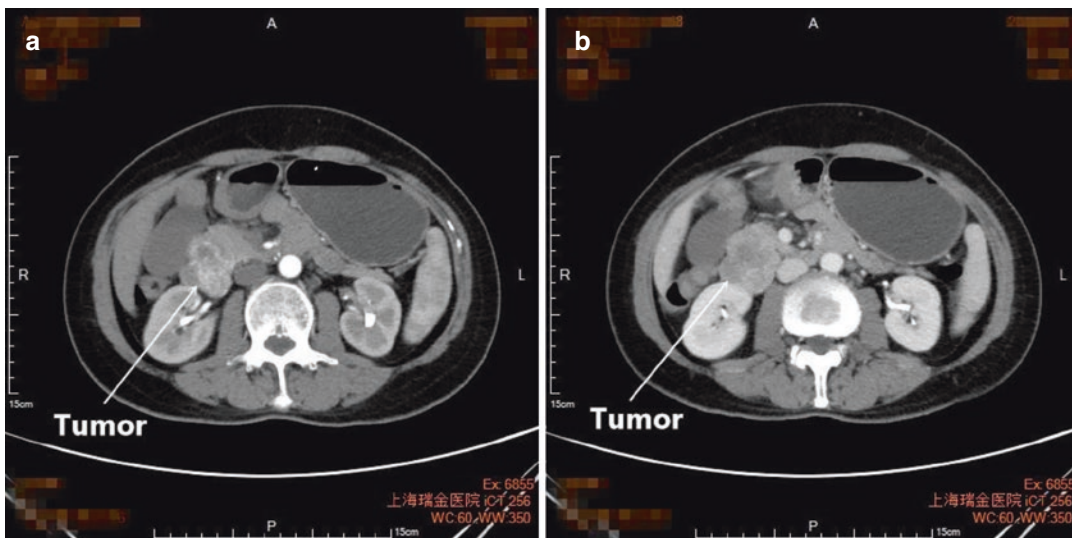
The CT scan of this patient, it showed the tumor was located at the duodenum near the ampulla
